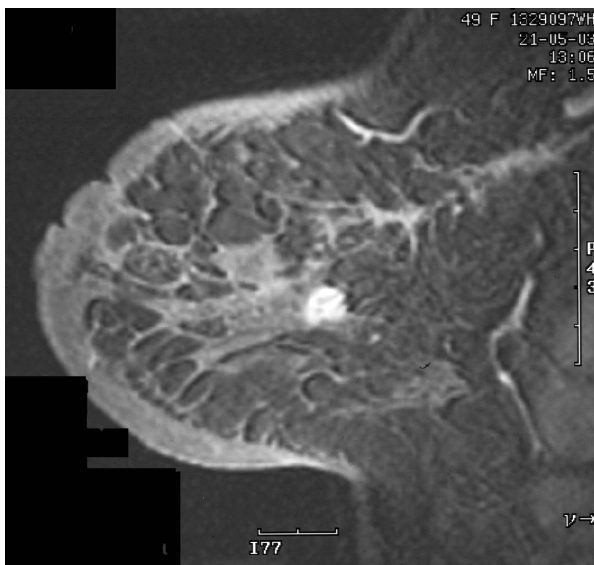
3D T1W gradient-echo MRI scan, with fat suppression, from a patient with a screen-detected cancer which was missed at excision. This post-contrast sagittal image clearly demonstrates an irregular enhancing malignant mass some distance from the linear enhancement seen in the surgical scar.
